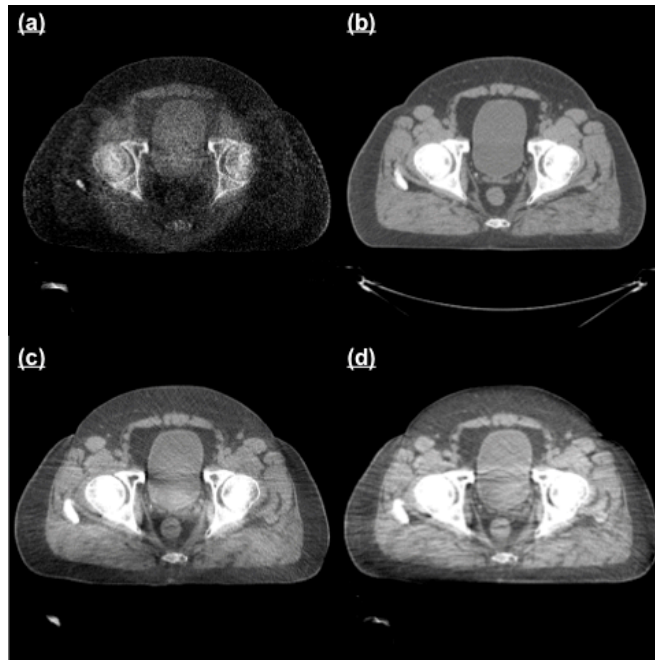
First example of successful shading corrected axial CBCT images (Patient A) amongst 20 sets of total sample size.
